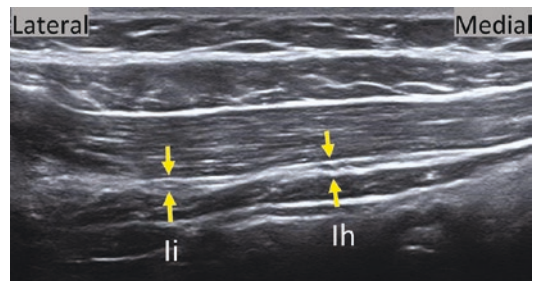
Transverse image of normal-appearing ilioinguinal (arrows li) and iliohypogastric (arrows, lh) nerves (short axis) using an 18 MHz ultrasound probe. Compared with the 9 MHz probe, the detail is greater with the 18 MHz probe; however, a fundamental trade-off exists between image resolution and depth of imaging in ultrasound. So, for patients with high body mass index, the resolution will need to be sacrificed to achieve adequate imaging depth
